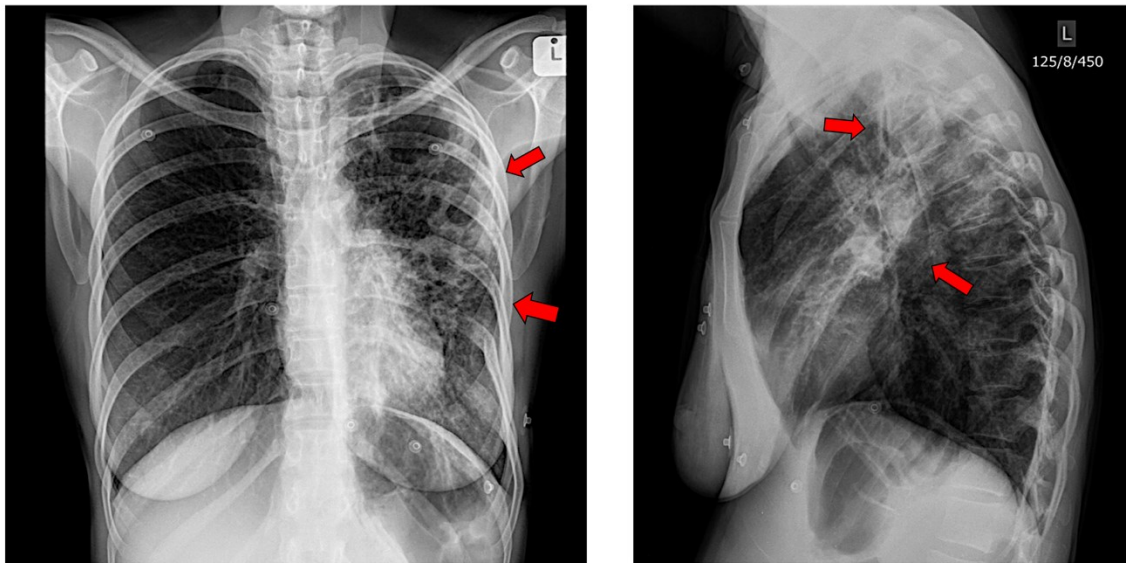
Example of a chest radiograph in case with AQP4-Ab-positive NMOSD and sputum positive TB. Left upper and middle zone cavities, with pulmonary infiltrates typical of reactivation TB.
